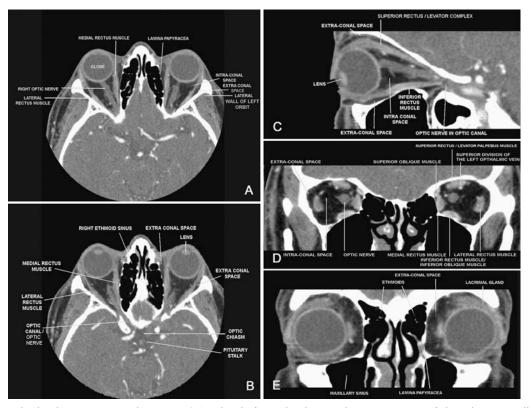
Axial orbital CT images with contrast (A) at level of the optic nerve and (B) showing the optical canal. (C) Parasagittal reconstruction of orbital CT along the course of the optic nerve. (D)
